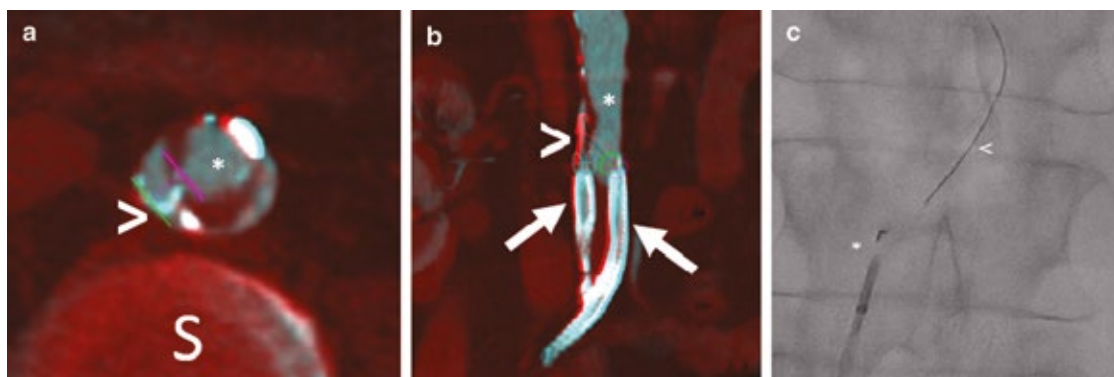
Axial (a) and coronal (b) cone beam computed tomography (CBCT) merged with pre-operative computed tomography angiography (CTA) showing the stents (arrows) in the false lumen, a virtual needle trajectory drawn between the true (asterisk) and false lumen (purple, green and light blue circles). The tip of a 0.014" guidewire is stuck at the top of the false lumen (arrowhead). (c) Outback re-entry catheter with the distal part in the false lumen (asterisk) and the opened sharp tip piercing the intimal flap. The tip of the guidewire (arrowhead) is passed through the flap into the true lumen.
